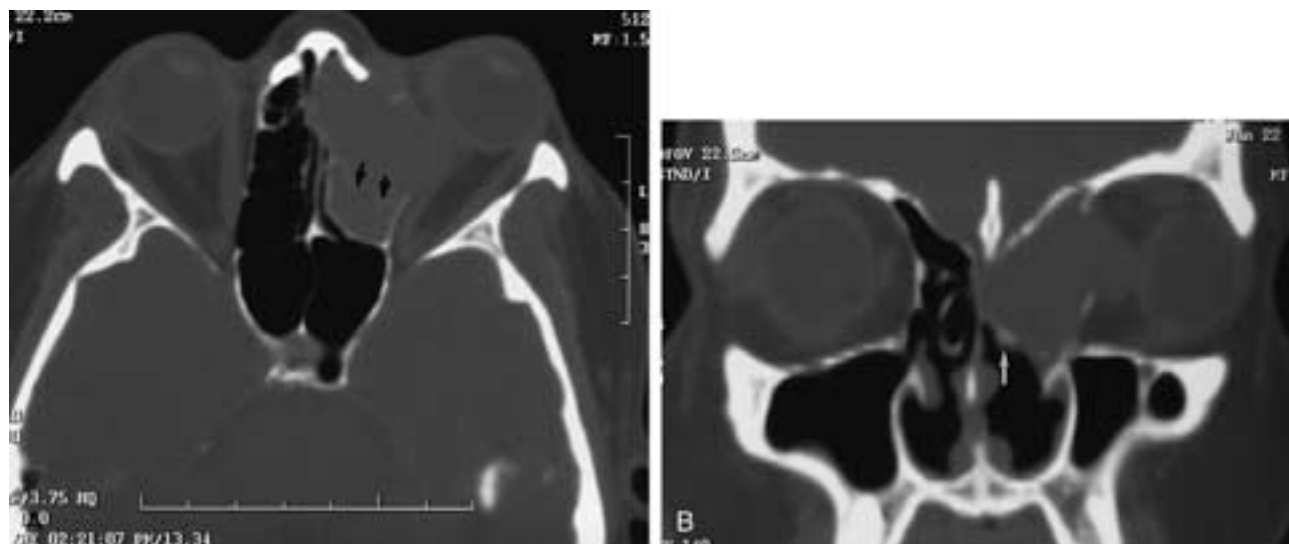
Post-FESS frontoethmoidal mucocoele, likely due to postoperative frontal recess stenosis. A, On the axial CT scan, 1-mm slice thickness, the left ethmoid sinus is airless and expanded. Deossification of the medial orbital wall results in poor visualization of the bony wall, and there is intraorbital, extraconal extension of the mucocoele. Note the posterior displacement of the anterior wall of the posterior ethmoid sinus (*arrows*). B, The high-resolution coronal reformation shows a prior septoplasty, resection of both inferior turbinates, with only the inferior aspect of the left middle turbinate remaining (*arrow*), and the large mucocoele. Recurrent frontoethmoidal recess stenosis from synechiae or mucosal disease likely led to the mucocoele. The patient complained only of proptosis.
